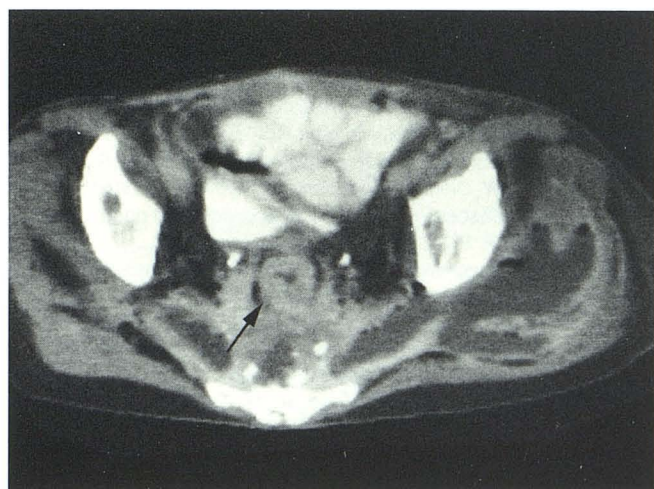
Case 12: severe bilateral sciatic symptoms. CT demonstrates rectum (arrow) to be anteriorly displaced by partly necrotic mass. Calcified densities in region of mass. Fluid collections extend into GSF bilaterally with air-fluid levels noted on left. Bilateral trans-GSF abscesses and recurrent tumor were diagnosed. Treatment was by percutaneous abscess drainage.
